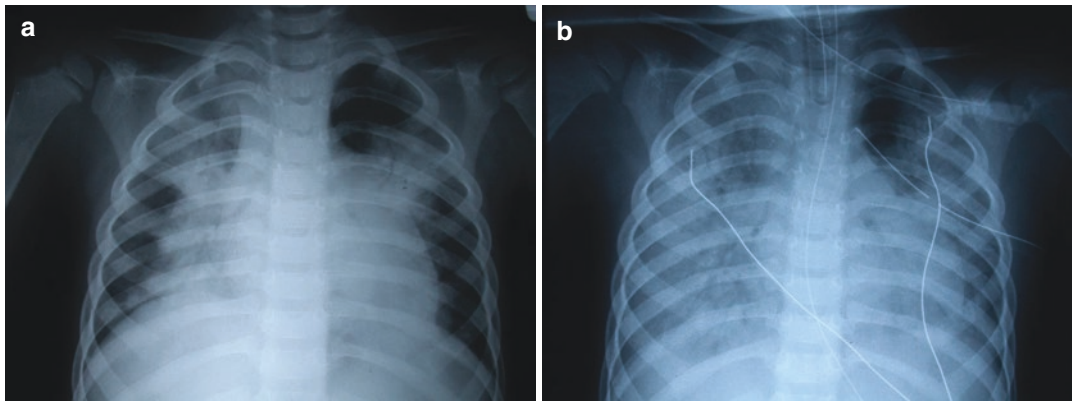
Chest radiography showed consolidation in right upper lobe, right middle lobe, and left upper lobe in a 2-year-old boy (Case 2) on admission (a) to a medical center and on hospital day 8 (b)
